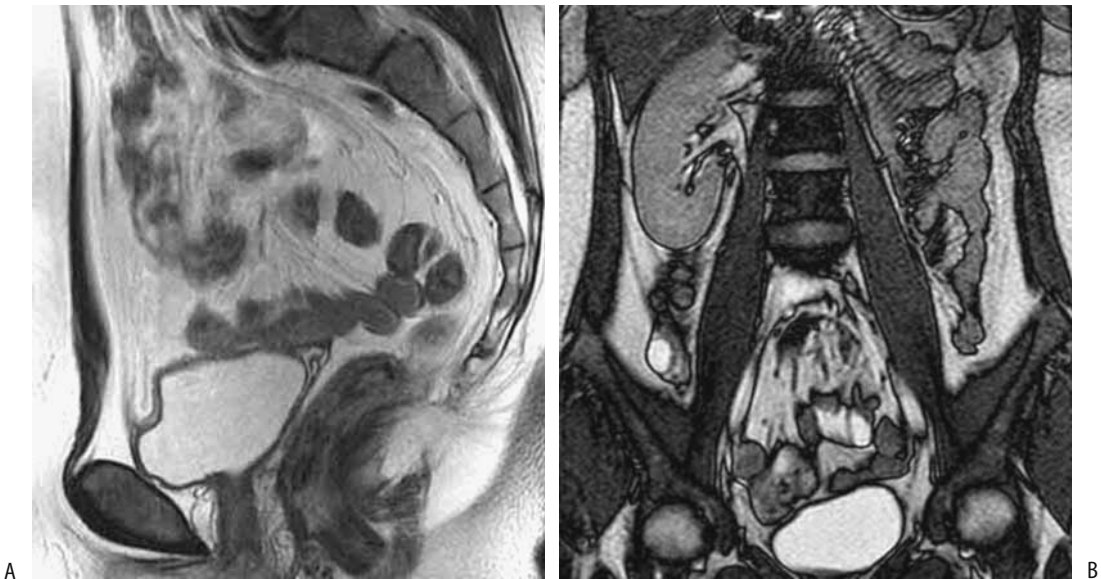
Uterine agenesis (Mayer-Rokitansky-Küster-Hauser syndrome.) A: Sagittal T2-weighted image shows absence of uterus and vagina. B: Coronal image confirms left renal agenesis. (Source: Imaoka I, Wada A, Matsuo M, Yoshida M, Kitagaki H, Sugimura K. MR imaging of disorders associated with female infertility: use in diagnosis, treatment, and management. *RadioGraphics* 2003;23:1401–1421, with permission from the Radiological Society of North America.)
